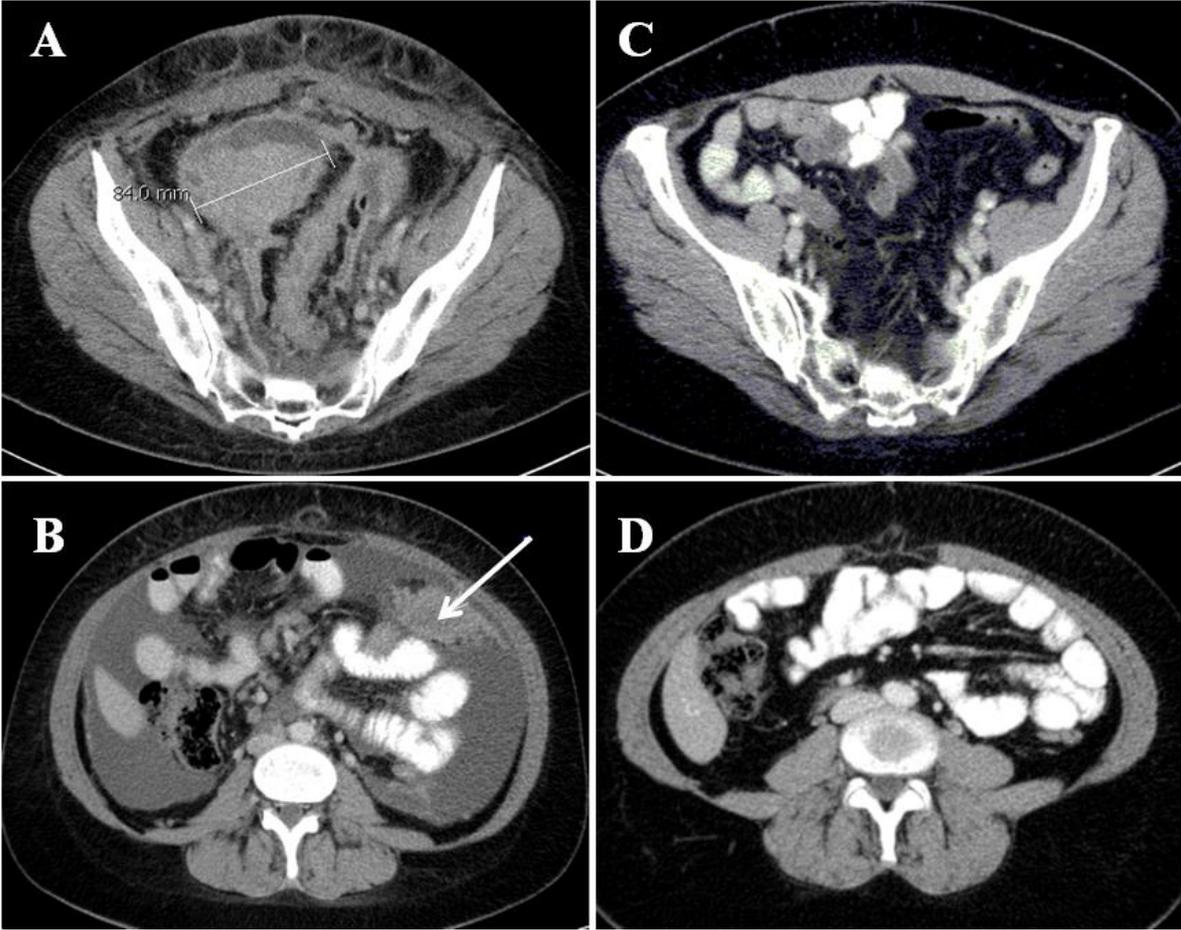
Axial CT slices of patient # 3 after contrast material was intravenously administered. A target lesion with a SLD of 84 mm is localized near the minor pelvis before (A) and after (C) six cycles of first-line chemotherapy. (B) The arrow represents a mesenteric peritoneal carcinosis (non-target lesion) in the same patient that is level with the lower edge of the liver prior to chemotherapy. A significant amount of ascites associated with the non-target lesion is also observed (B). (D) Both non-target lesions are absent after the completion of chemotherapy.
